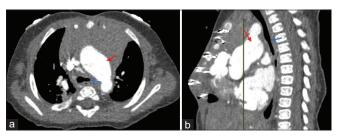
(a) Axial and (b) Sagittal computed tomography imaging showing that the left mainstem bronchus near the carina (blue arrow) is no longer externally compressed by the nearby Damus– Kaye–Stansel anastomosis (red arrow)
